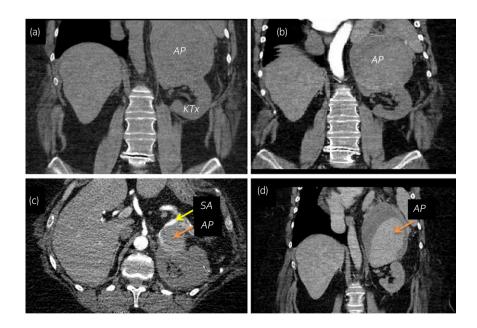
Computed tomography angiogram (CTA) images demonstrating pseudoaneurysm formation of the splenic artery just proximal to the endto-end splenic artery to donor renal artery anastomosis. (a) Pre-contrast image showing a $12.0 \times 10.5 \times 12.8$ cm pseudoaneurysm. (b and c) Arterial phase imaging highlighting the poor enhancement of the transplant kidney. Yellow arrow identifies the splenic artery leading to the pseudoaneurysm (orange arrow). (d) Delayed phase imaging showing delayed filling of the pseudoaneurysm.
